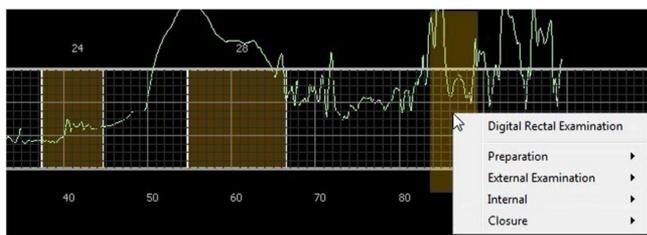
Task annotation based on CTA. Pressure plot pane is used to select intervals (shaded brown areas) in order to label an observed task (number above intervals indicate task ID), particularly those tasks related to the internal examination stage that are possible to see through our system.
